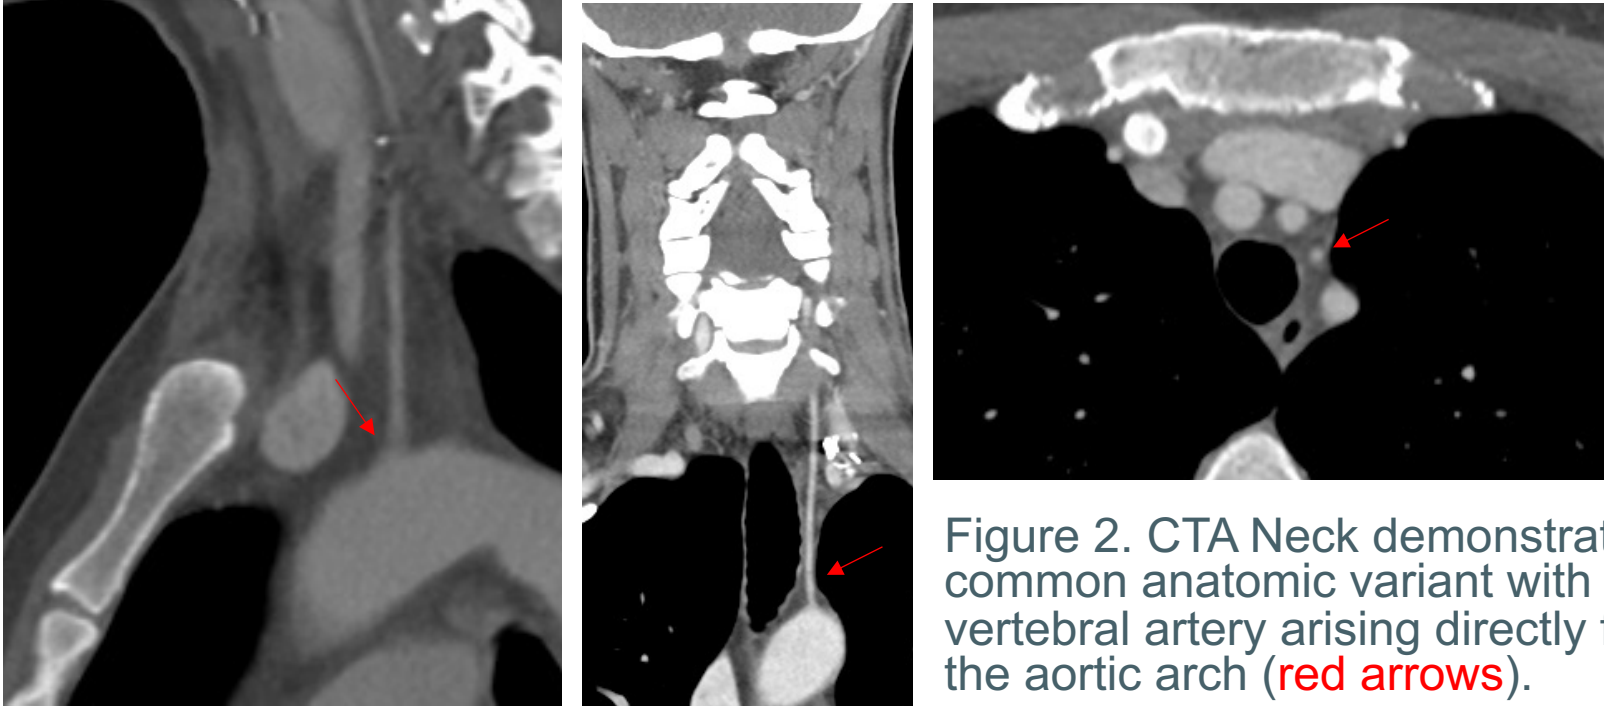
CTA Neck demonstrating common anatomic variant with left vertebral artery arising directly from the aortic arch (red arrows).
